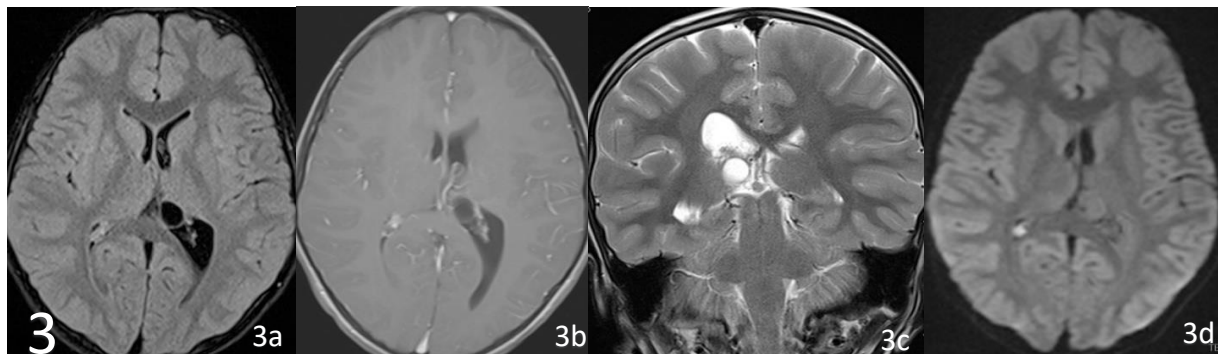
Last MRI 8 years later revealing further reduction in size of the cyst
